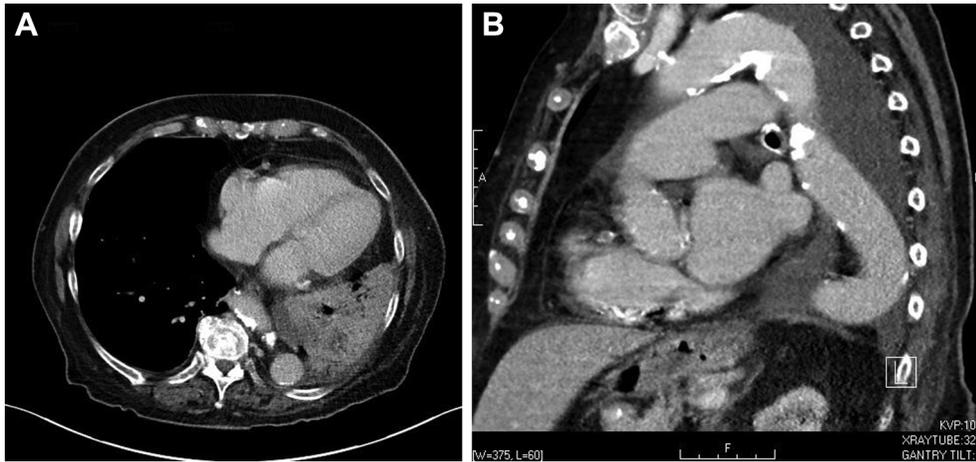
CT scan (A, axial view; B, sagittal view), demonstrating the thoracic aorta coursing very near the posterior chest wall just deep to the ribs.
